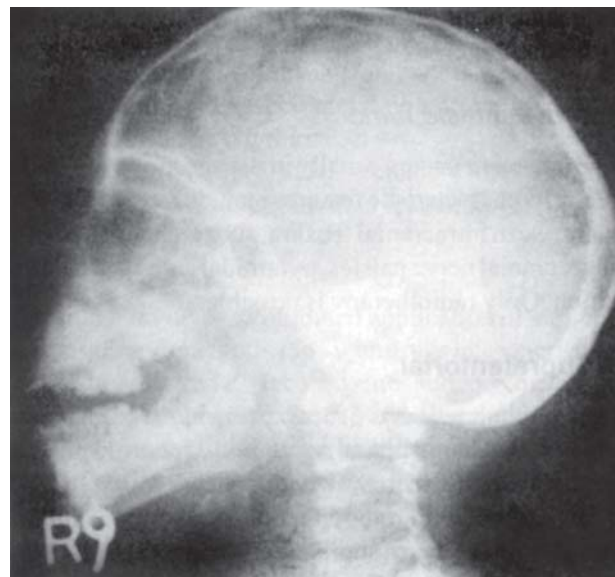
Skull X-ray, showing silver-beaten appearance in a child with brain tumor
